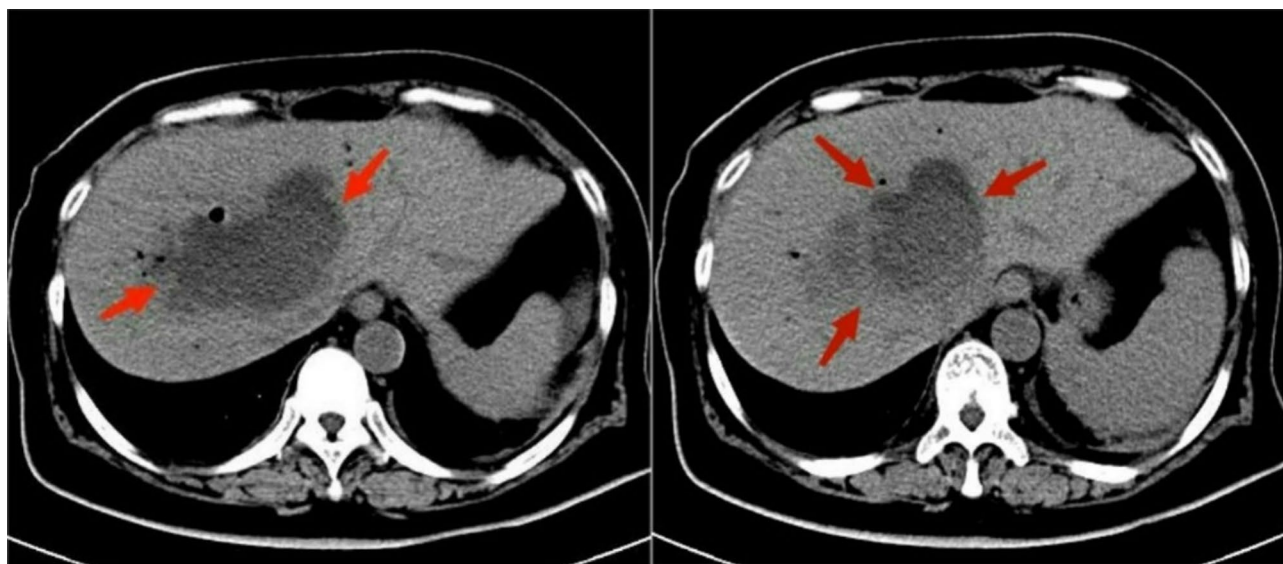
Abdominal CT showing a liver abscess (red arrow)
